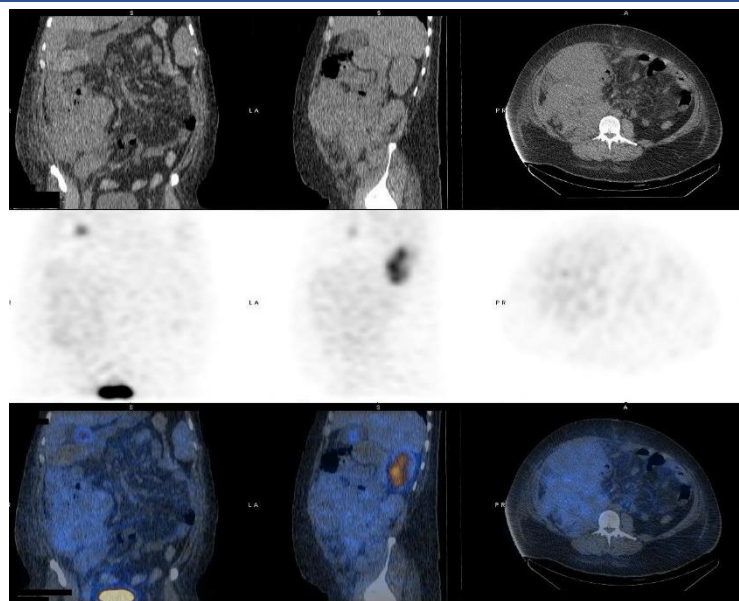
Upper, middle, and lower rows show CT, [^{99m}Tc]Tc-EC SPECT, and [^{99m}Tc]Tc-EC SPECT-CT images, respectively. They show urinary leak secondary to ureter injury and perinephric urinoma; from left to right on coronal, sagittal, and horizontal axes, respectively
